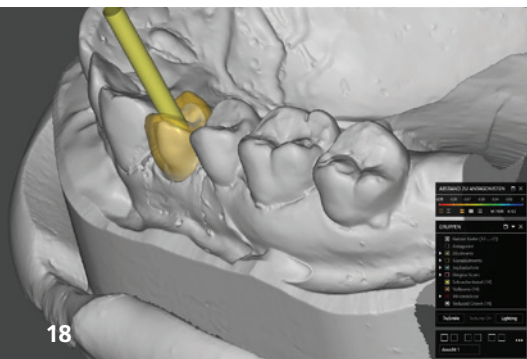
CAD/CAM design of the final restoration (fully veneered zirconia hybrid abutment crown). – Figs. 19+20: Definitively placed hybrid abutment crown on implant #14 – Fig. 21: Radiograph of implant #14 with final crown in place.
